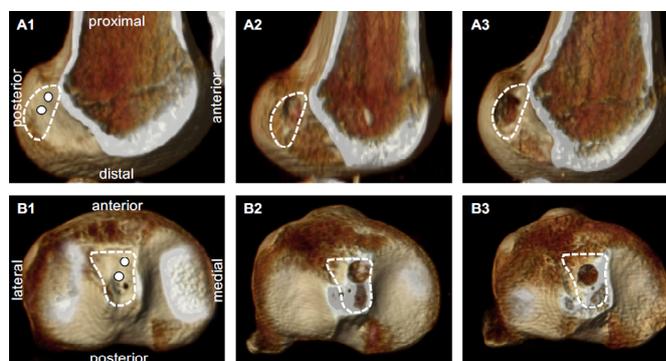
Rendered 3D computed tomography of the anatomical reconstruction of the anterior cruciate ligament. A1 and B1: representative position of the anteromedial tunnel (upper white dot) and central tunnel (lower white dot) in the femur and tibia, respectively; A2 and A3: anteromedial and central tunnels in the femur, respectively; B2 and B3: anteromedial and central tunnels in the tibia, respectively.
